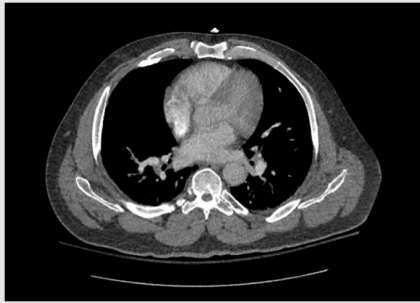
Mediastinal Chest CT with Contrast.
